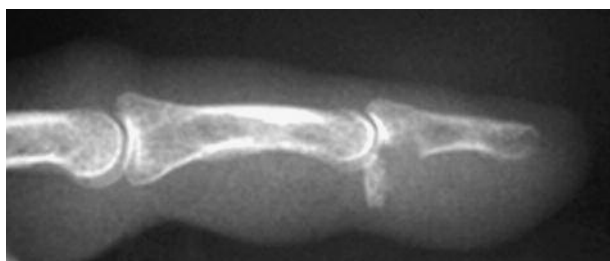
Lateral radiograph showing a Leddy and Packer Type III FDP avulsion fracture at the base of the distal phalanx (17).
